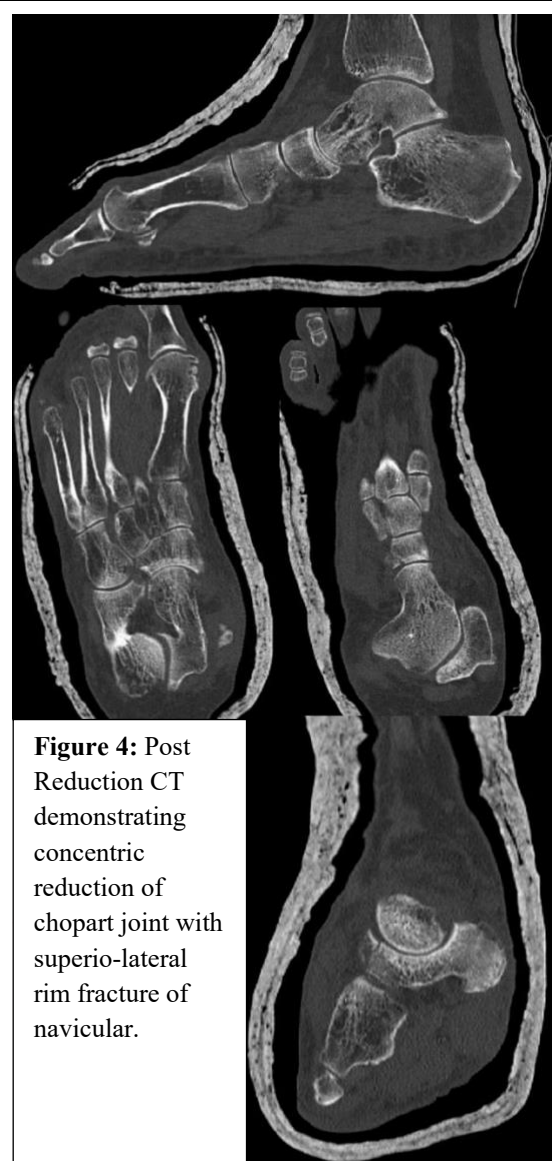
Post Reduction CT demonstrating concentric reduction of chopart joint with superio-lateral rim fracture of navicular.
